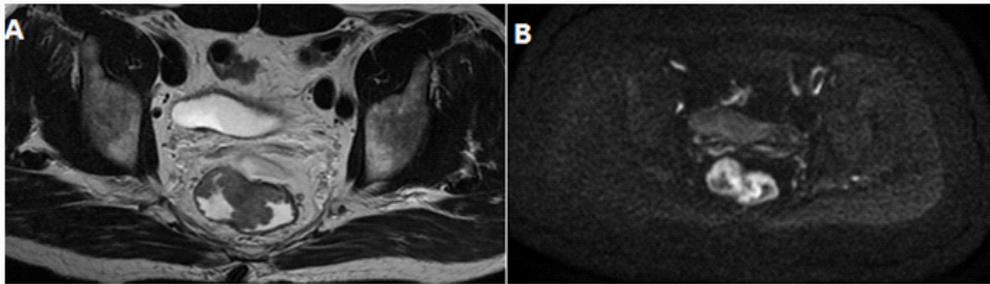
On Magnetic Resonance Imaging (MRI), a cauliflower-like mass which occupied 3/4 to nearly all of the rectal lumen infiltrated a small portion of muscularis propria, indicating malignancy. Mesorectal Fascia (MRF) was negative and no obvious metastatic lymph nodes were evident. High signal intensity and rapid enhancement on T2-weighted images (A) and Diffusion-Weighted Magnetic Resonance Imaging (DWI) (B).
